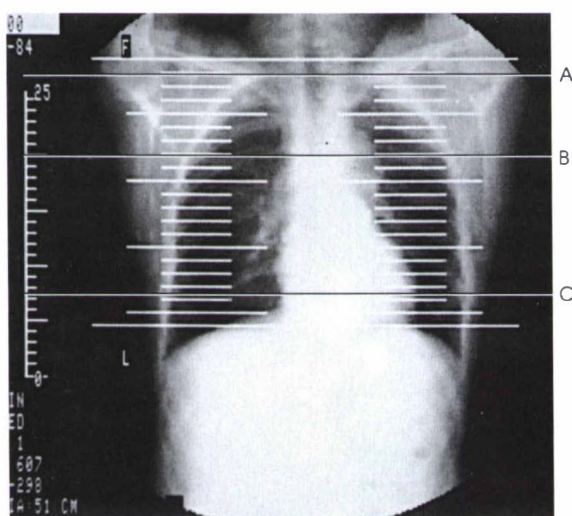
CT localizer (scout) image of thorax.
